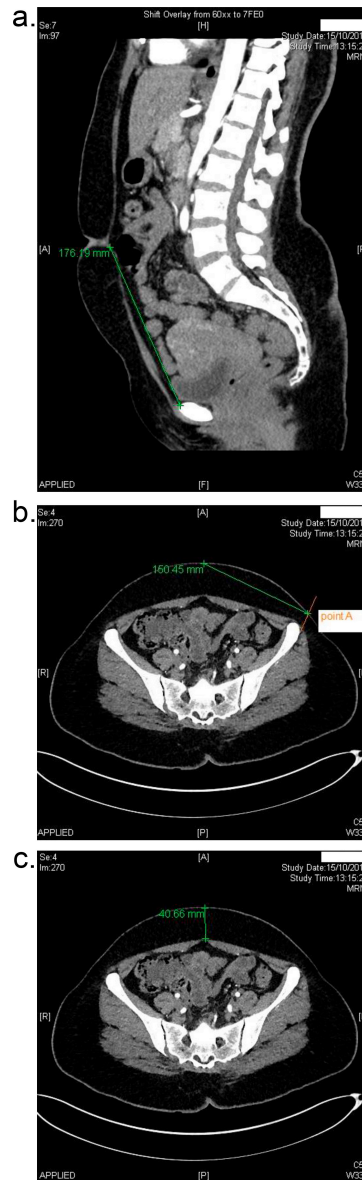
Depiction of how the parameters of the prism are measured using a patient's CT angiogram. a. Measurement of the base using the midline sagittal view. b. Measurement of the height using an axial slice at the level of the anterior superior iliac spines and the sacral promontory. c. Thickness of the flap measured on the same axial slice as b from the skin to the linea alba.
